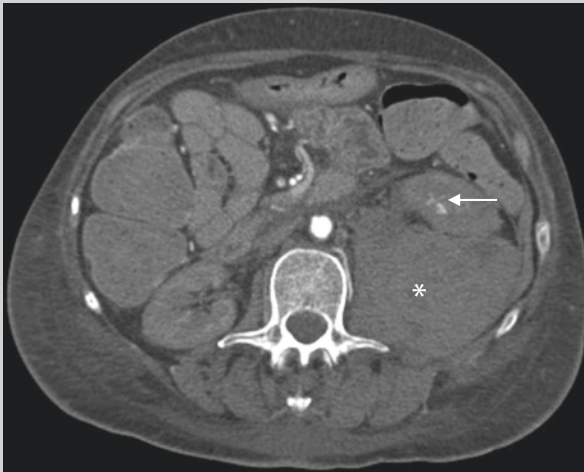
Contrast enhanced arterial phase CT of the abdomen showing anterior displacement of the left kidney by a large perinephric haematoma (*asterisk*). There is a focus of active arterial haemorrhage in the lower pole of the left kidney (*arrow*)
